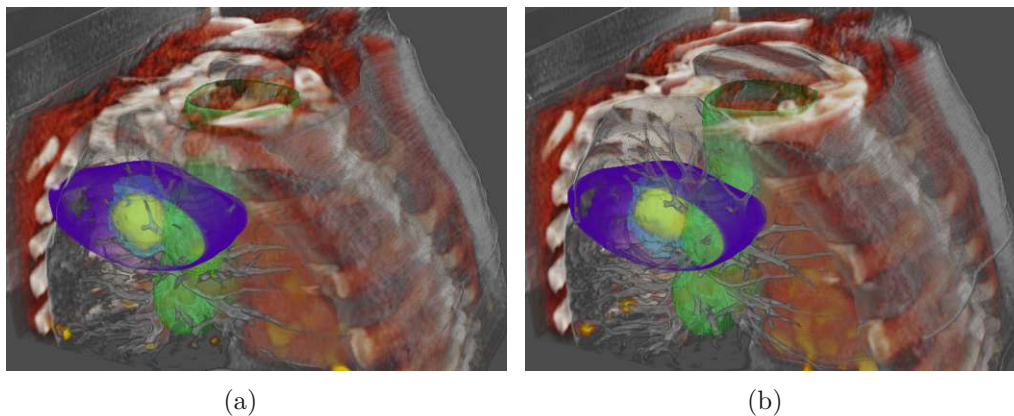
Fusion of 4D-PET/CT with segmentation data sets (ITV, SMT) and the 15 Gray isodose surface. (a) and (b) show different time bins of the patients' breathing cycle. Clipping was applied to hide parts of the thorax.
